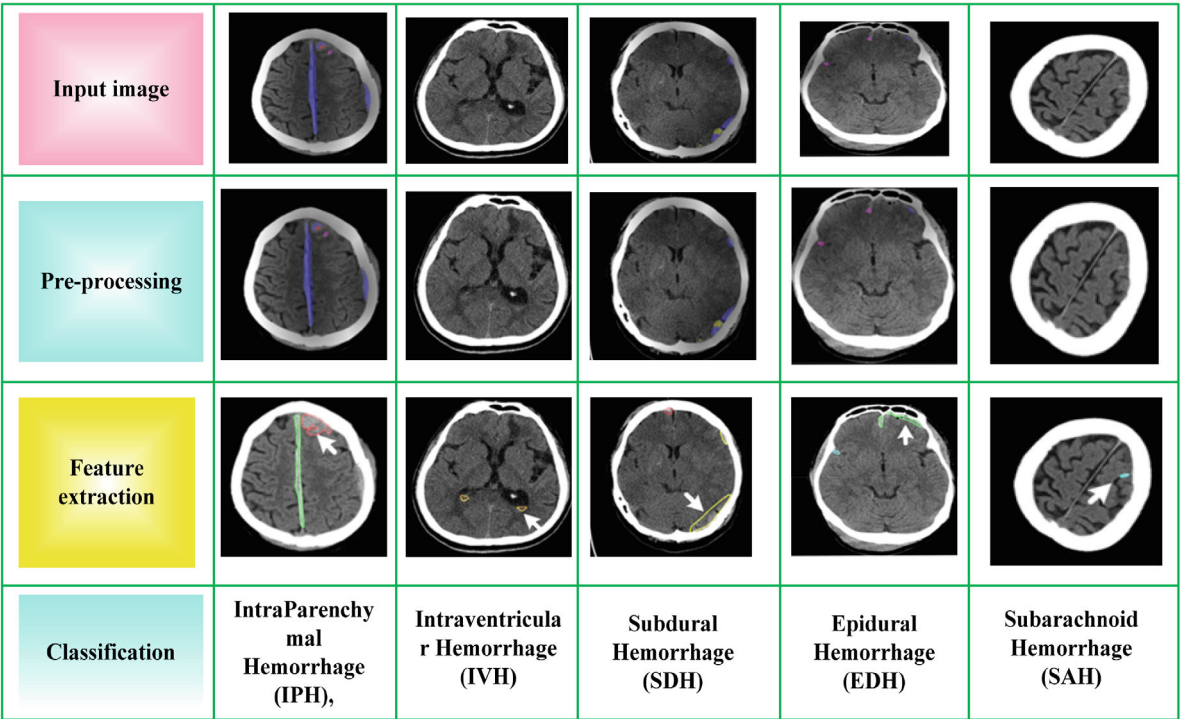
Automated detection and classification subtypes of intracranial hemorrhage (IPH, IVH, SDH, EDH, SAH) using brain CT scans
